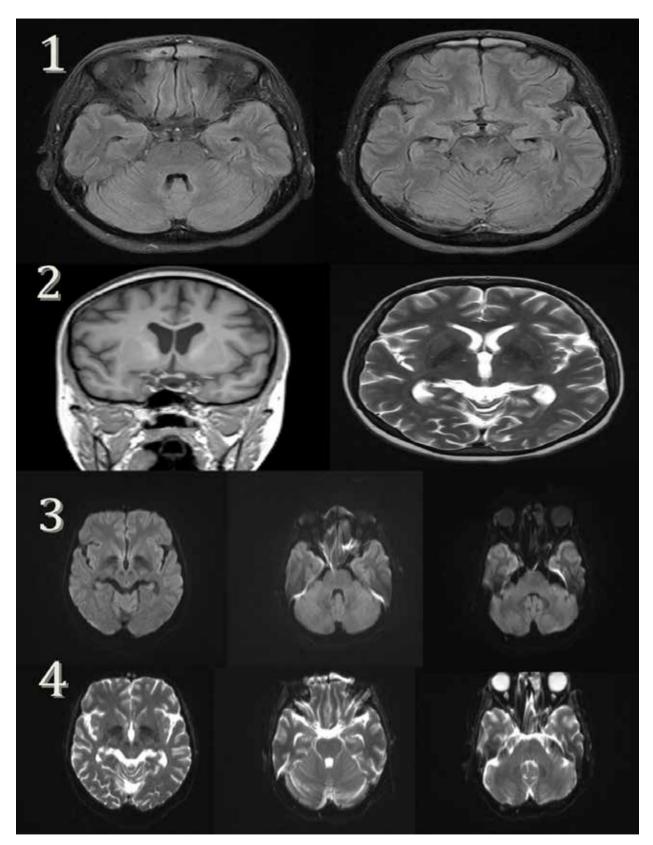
Multiplanar multi sequential MRI without IV contrast administration. Normal brain MRI. (1) FLAIR image MRI of the brain showed the normal signal intensity of medial aspect of temporal lobes and inferomedial aspect of frontal lobes. (2) Coronal T1 and axial T2 images showed the normal signal intensity of bilateral temporal lobes and insular cortices. (3 & 4) Diffusion-weighted imaging and apparent diffusion coefficient showed no abnormal restricted diffusion.
